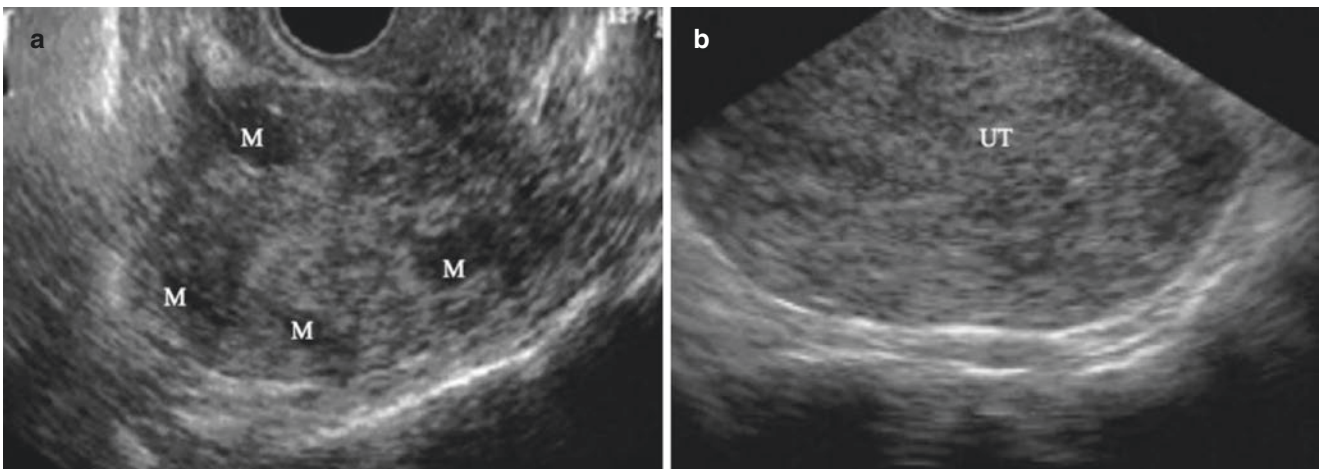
Differential diagnosis of leiomyoma and uterine hypertrophy. (a) Small fibroids with boundary in a normal-shaped uterus. (b) Sonogram shows the enlarged uterus in a normal shape, without intramural lesion
